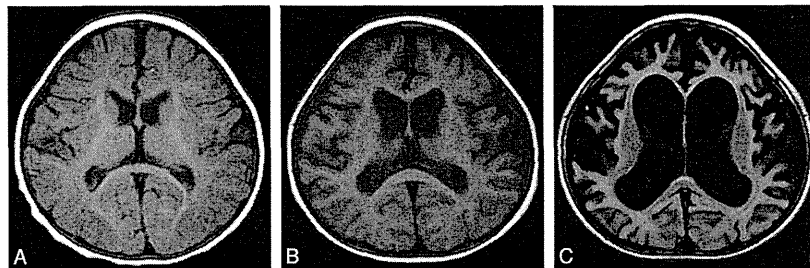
Type 5. Progressive brain atrophy. Sequential change of brain MR imaging of patient 27 with an *ATRX* mutation in int 35 (c.7200 + 4A>G, p.L240Ifs) at 6 months (T1WI) (A), 14 months (T1WI) (B), and 34 months (FLAIR) (C).
